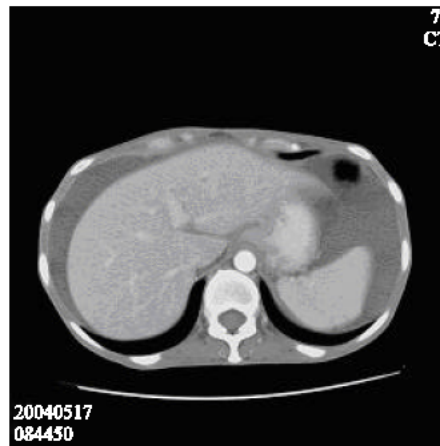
Massive ascites in the abdominal CT
